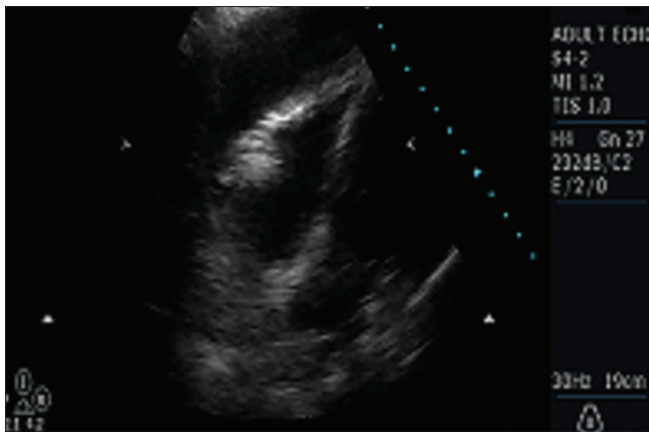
Echocardiographic picture of pericardial effusion
